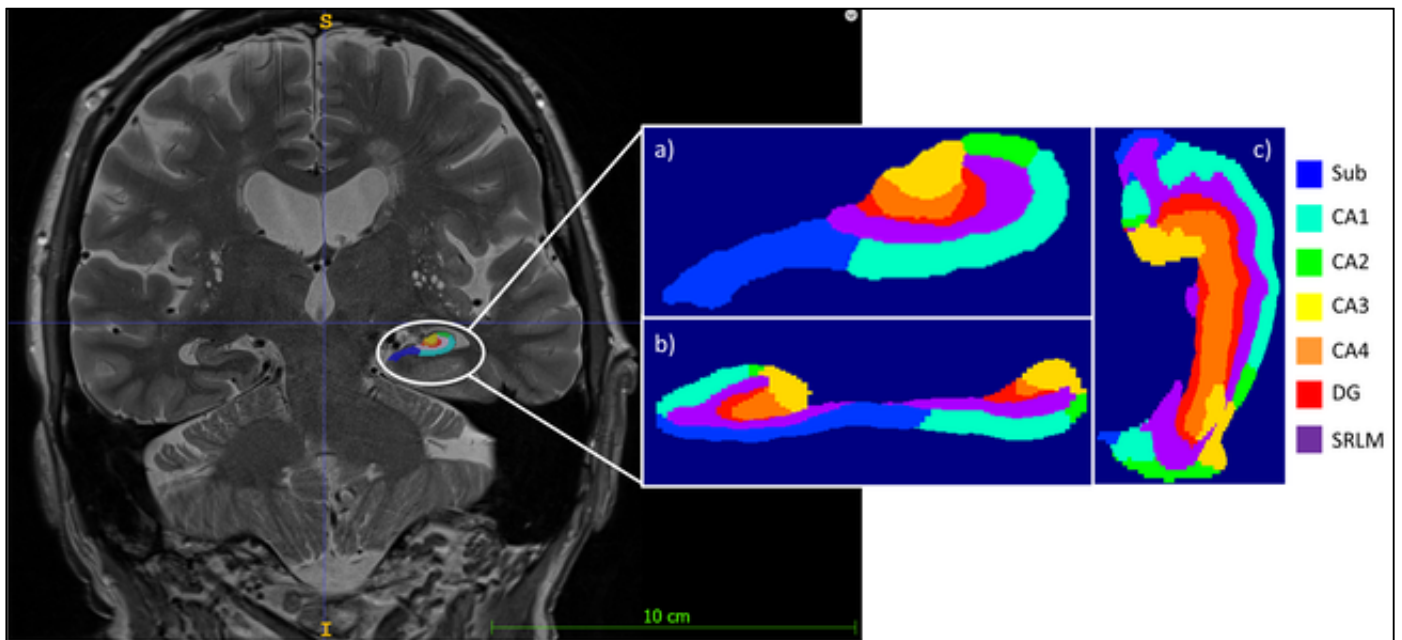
High resolution T2-weighted MR Images were processed with a novel automated segmentation software [Hippunfold] to measure hippocampal subfield volumes throughout the entire hippocampal long axis. Volumes were then compared with neuropsychological test scores, as well as CSF and PET biomarkers. Subfield labels are shown in the a) coronal plane, b) sagittal plane, and the c) axial plane. Sub= Subiculum, CA = Cornu Ammonis, DG = Dentate gyrus and SRLM=stratum radiatum, Lacunosum, and moleculare.
